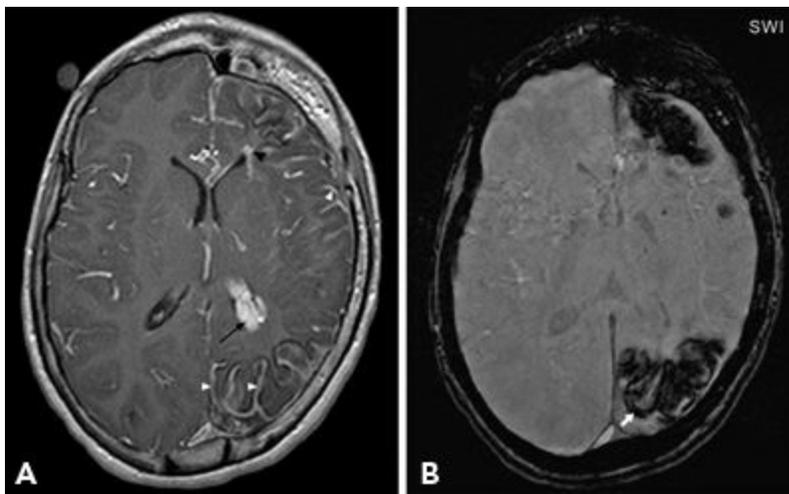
Contrast-enhanced T1-weighted image (A), and susceptibility-weighted image (SWI) (B) in a child with Sturge–Weber syndrome. Contrast study shows enlarged periventricular veins (black arrowhead), abnormal leptomeningeal (white arrowheads), and choroid plexus enhancement (black arrow). SWI is superior to visualize the extent of cortical abnormality (arrow). Also, note diffuse left hemispheric atrophy and thickening of ipsilateral calvarium. (Courtesy of Dr. Ingrid Tuxhorn, Cleveland, OH.)
